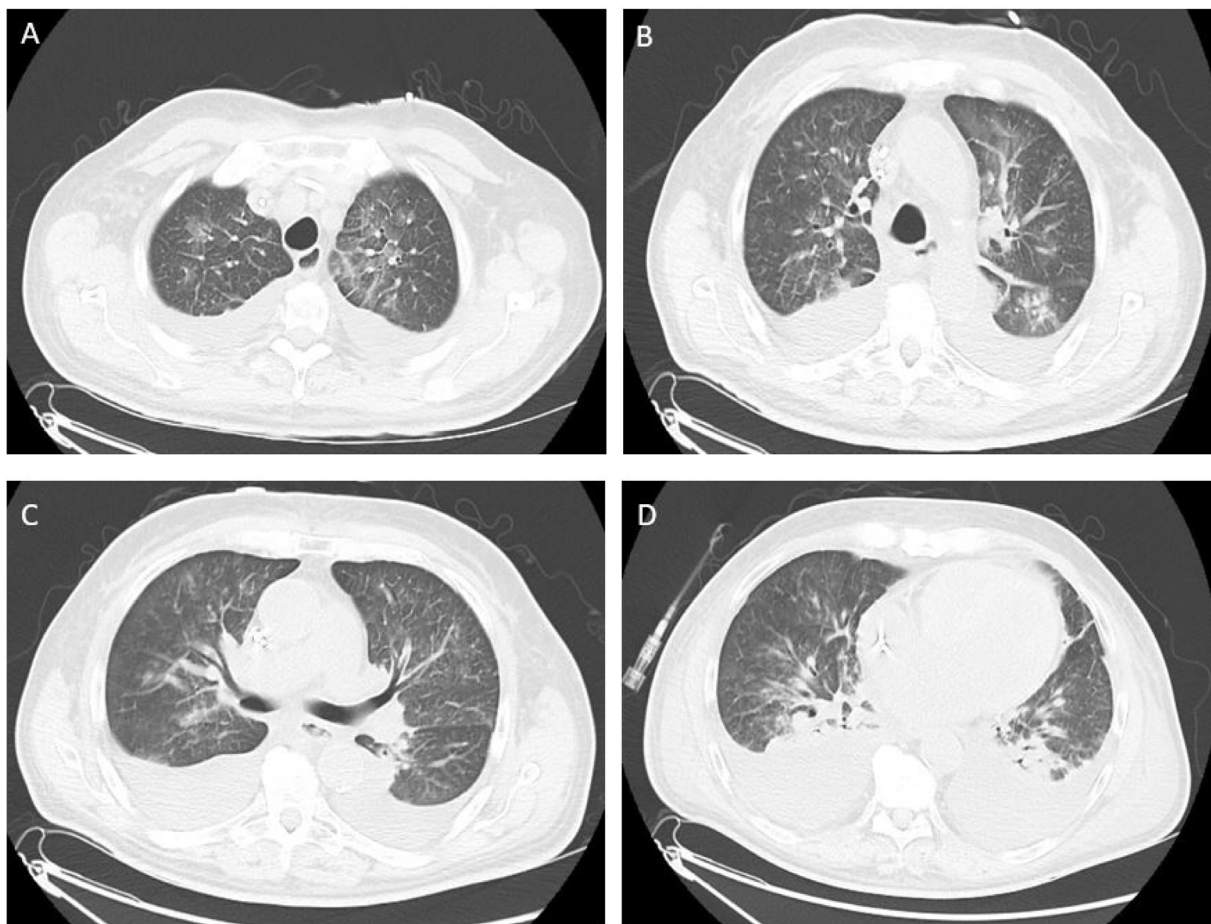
Computed tomography scan images showing new multifocal bilateral ground-glass opacities and consolidations with smooth interlobular septal thickening, superimposed pulmonary edema, and moderate bilateral pleural effusions with bibasilar atelectasis.
